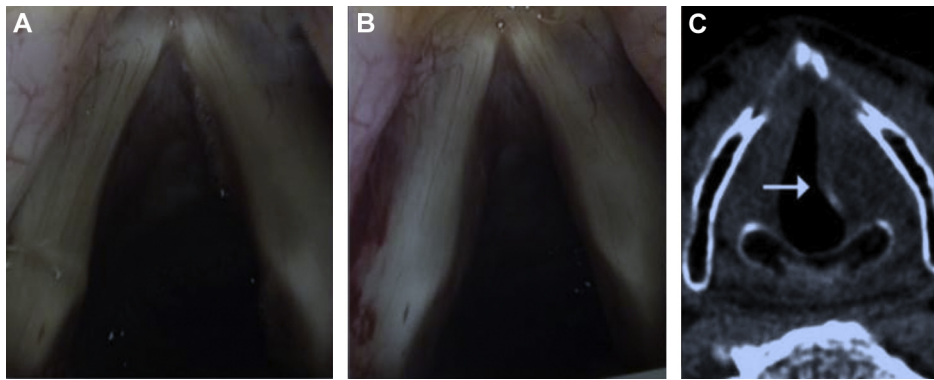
Endoscopic view of left laryngeal palsy. A. Aspect before injection. B. Aspect after Restylane® injection to the left vocal fold. C. CT aspect after Restylane® injection to the left vocal fold.
